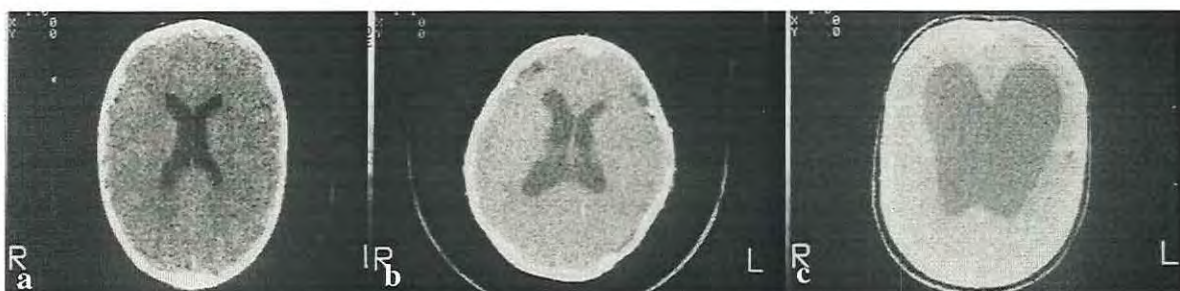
Ventricular patterns found on CT scan in patients with Crouzon syndrome. (a) Mild enlargement. (b) Moderate enlargement. (c) Severe enlargement/hydrocephalus.
